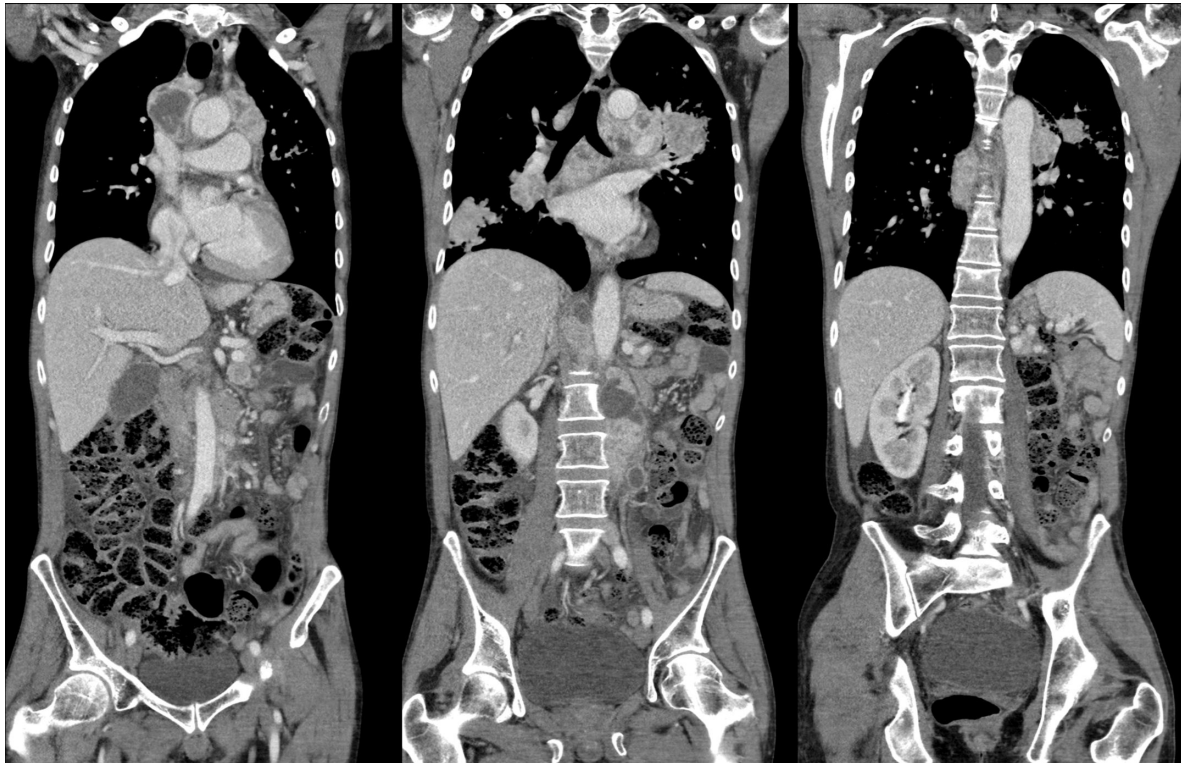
Example of a coronal reconstruction of CT images acquired at Hospital La Fe.
